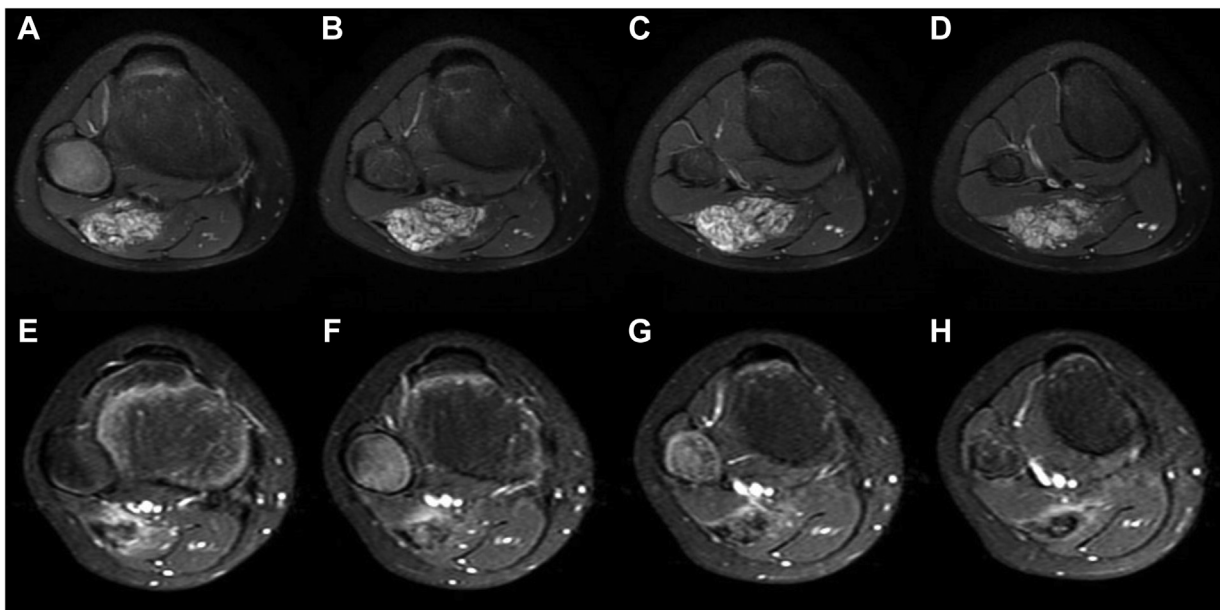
A magnetic resonance imaging (MRI) comparison before and nine months after ablation of an intramuscular fibro adipose vascular anomaly (FAVA) lesion in the lateral gastrocnemius of the upper right lower leg in a 9-year and 5-month-old patient. (A-D) Preoperative T2-weighted images (fat-suppressed) show the lesion as a hyperintense T2 signal. (E-H) Contrast-enhanced MRI (T1 fat-suppressed) obtained 9 months after ablation demonstrates the absence of blood supply in the ablated tumor region.
